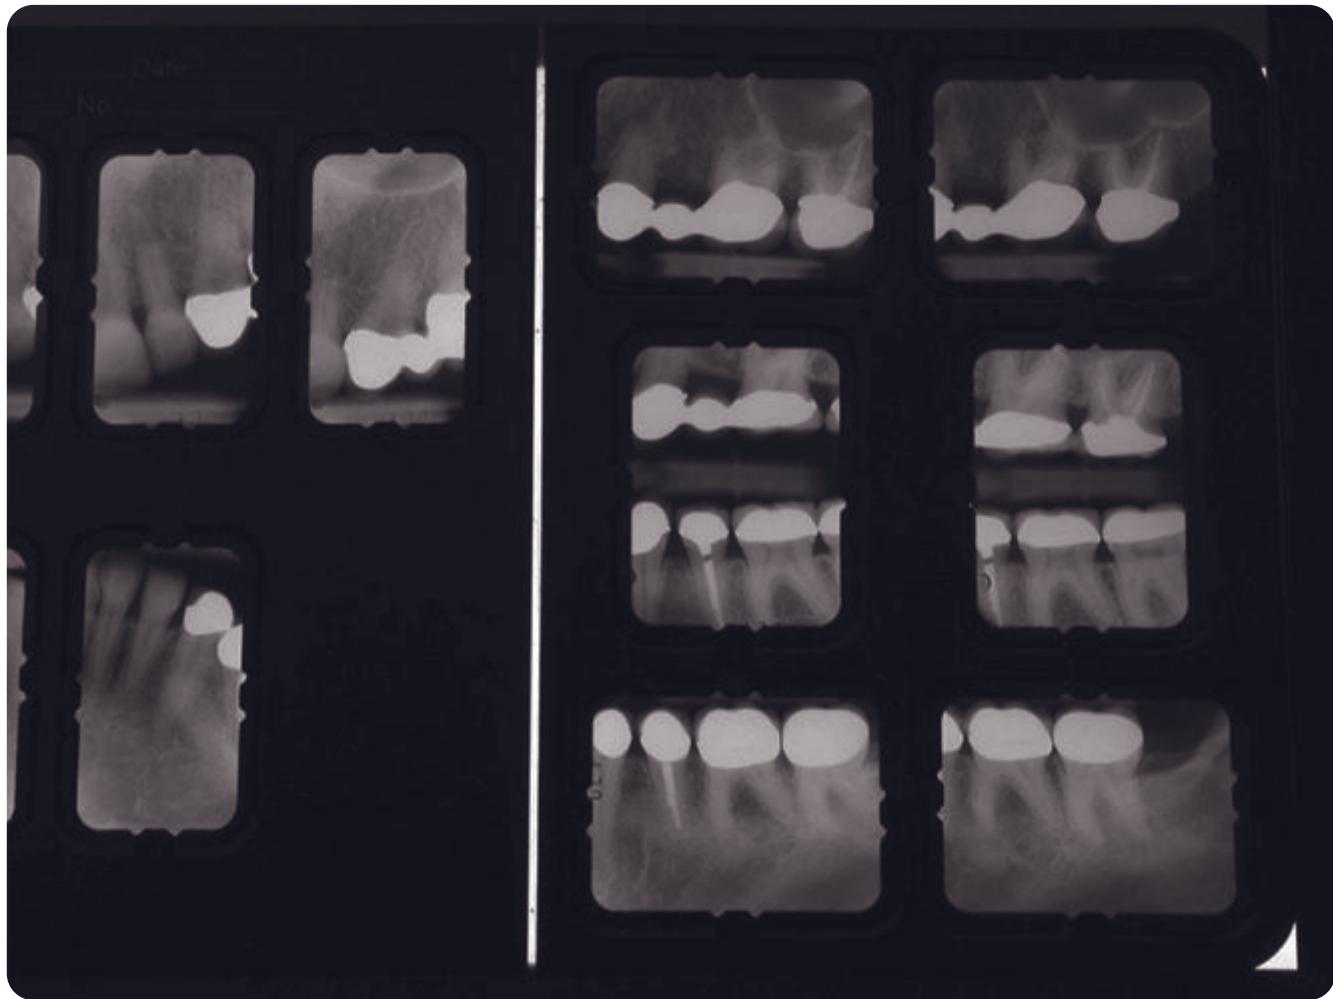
Posttreatment panoramic radiograph. Elective endodontics was done on the lower bicuspids. Endodontics was necessary during provisionalization on 8 and 15 because of irreversible pulpitis.
